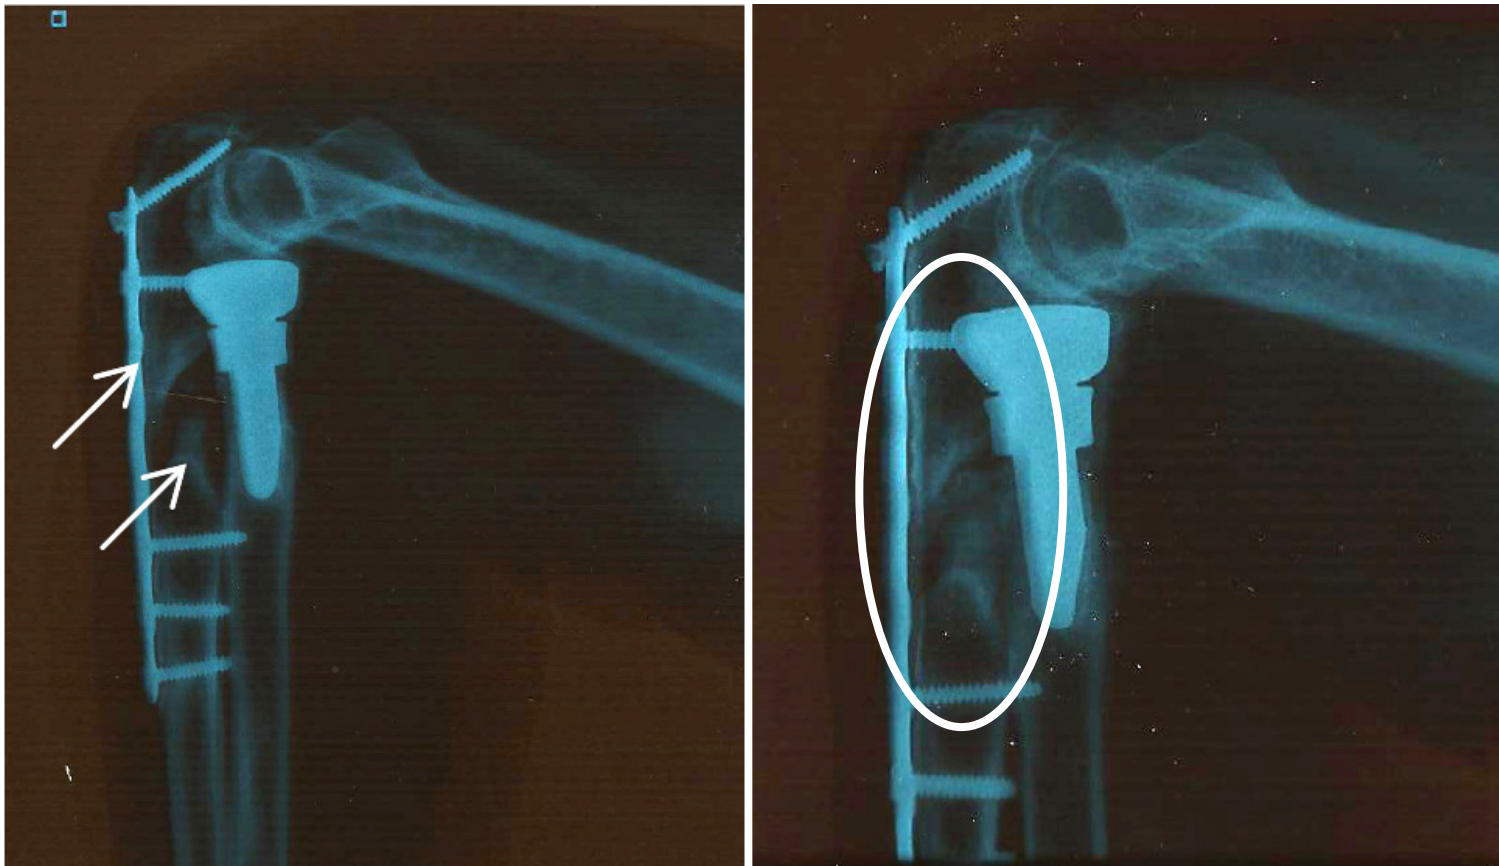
X-ray of patient 10 a) before and b) 16 weeks post-injection with PRP around the non-union of the right arm. The arrows in a) indicate the non-union and absence of cortical bone before treatment with PRP. The oval in b) indicates the area 16-weeks post-treatment with an increase in bone density and cortical bone formation.
